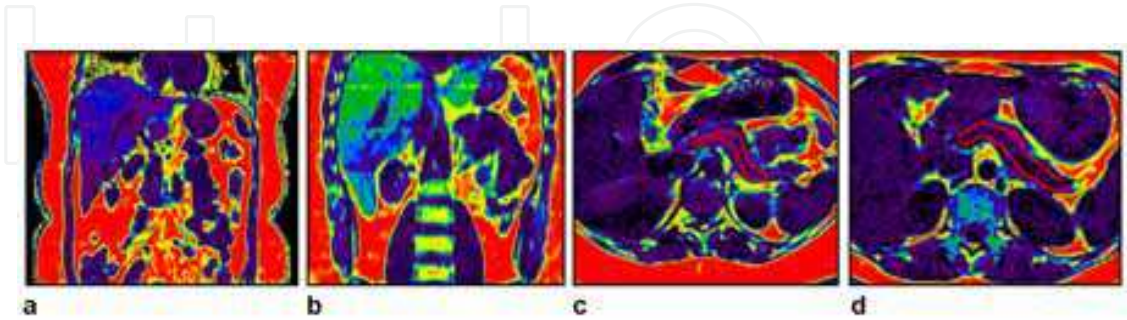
IDEAL fat fraction (FF) MRI. (a, b) IDEAL-reconstructed FF maps of the liver in two subjects, shown in the coronal orientation. The 3D nature of IDEAL data facilitates visualization of the FF map from any perspective. Same color bar as Fig. 12. Note that SAT and VAT distributions can be clearly seen, along with varying degrees of fat accumulation in the liver. (c, d) Two examples of pancreas (red outline), with an average 11% and 5.1% percent FF within the traced regions, respectively.
